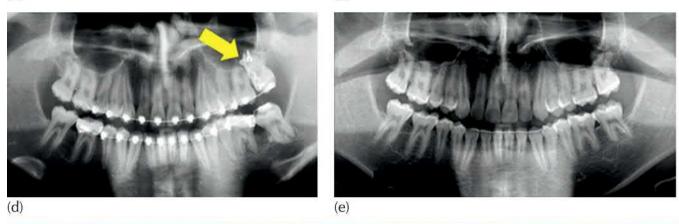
(a) The pre-treatment intra-oral views of the teeth in occlusion. (b) Panoramic radiograph taken by the general dentist at the routine dental examination. (c) Panoramic view taken one year after third molar extractions, immediately after placement of orthodontic appliances and following surgery to place zygomatic plate temporary anchorage device (TAD; arrow) in the maxilla and an attachment bonded to the distal crown surface of the mandibular left second molar. (d) Panoramic view taken before removal of the zygomatic plate TAD (arrow), after eruption of the maxillary second molar and resolution of the mandibular molar impaction. (e) The completed case with mandibular 3-3 fixed retainer. (f) The completed case.
